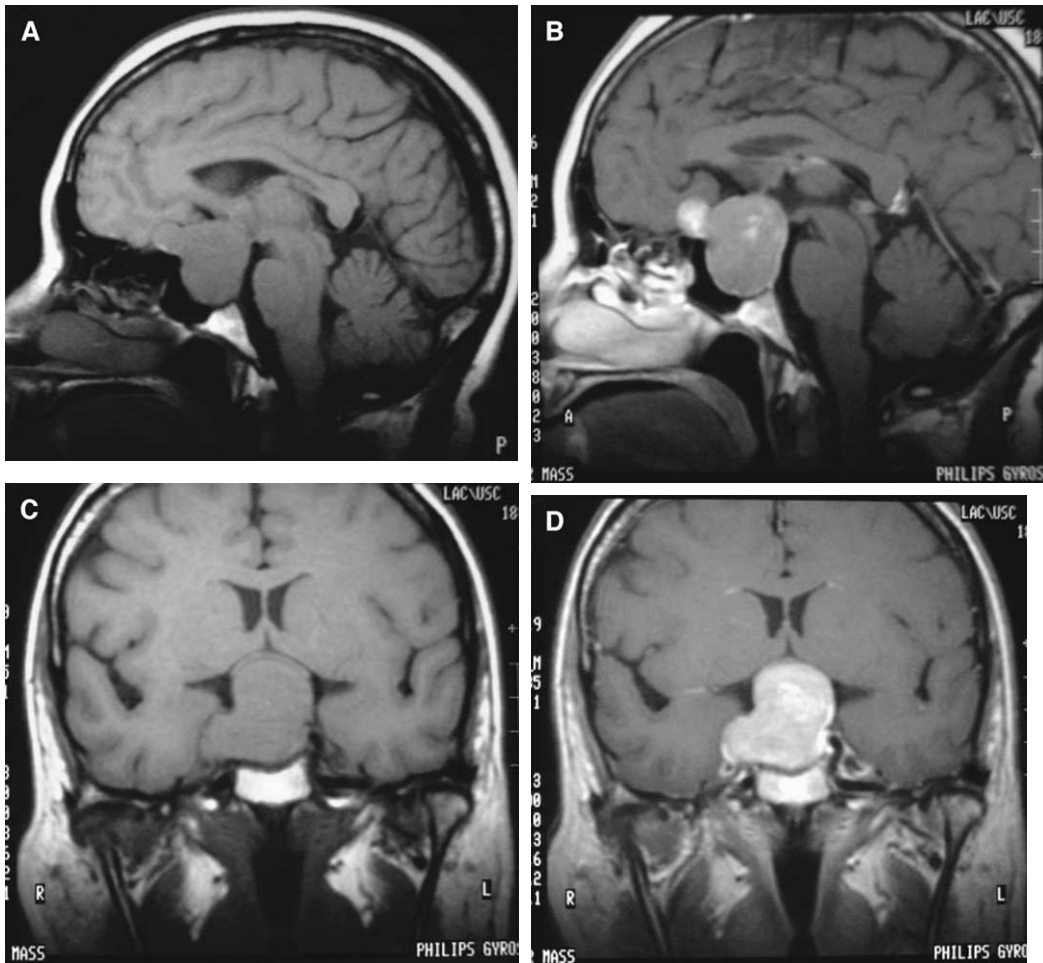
Macroadenoma. (A) Sagittal T1-weighted image shows a large isointense sellar mass with suprasellar extension, which extends into the subfrontal region. The optic chiasm is markedly compressed and cannot be identified. Remodeling of the floor of the sellar turcica is also seen. (B) Sagittal postcontrast T1-weighted image demonstrates enhancement of the large mass lesion, with more enhancement seen in the subfrontal component. (C) Coronal T1-weighted image shows a large mass with suprasellar extension and marked compression of the optic chiasm. Extension of the mass into the right cavernous sinus is also seen. (D) Coronal postcontrast T1-weighted image shows enhancement of the large sellar mass.
